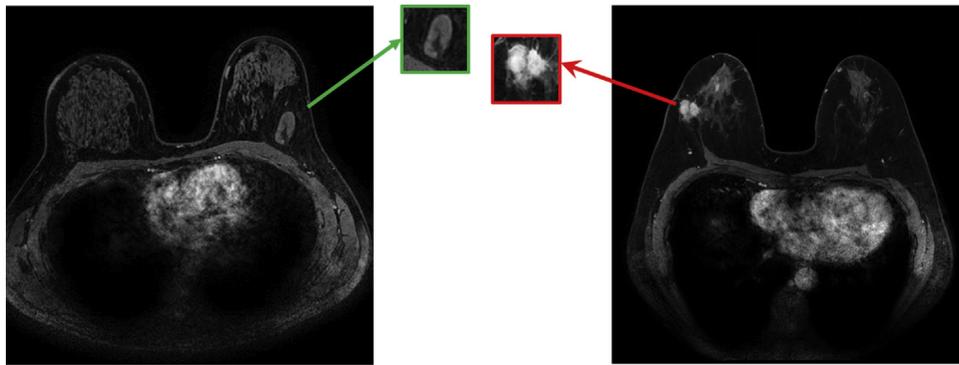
Examples of DCE-MRI transverse center slices with the corresponding regions of interest (ROIs) extracted. On the left is a benign case and on the right is a malignant case. These extracted ROIs are then input to a CNN for transfer learning. DCE = dynamic contrast-enhanced MRI. (Reprinted with permission [37])
